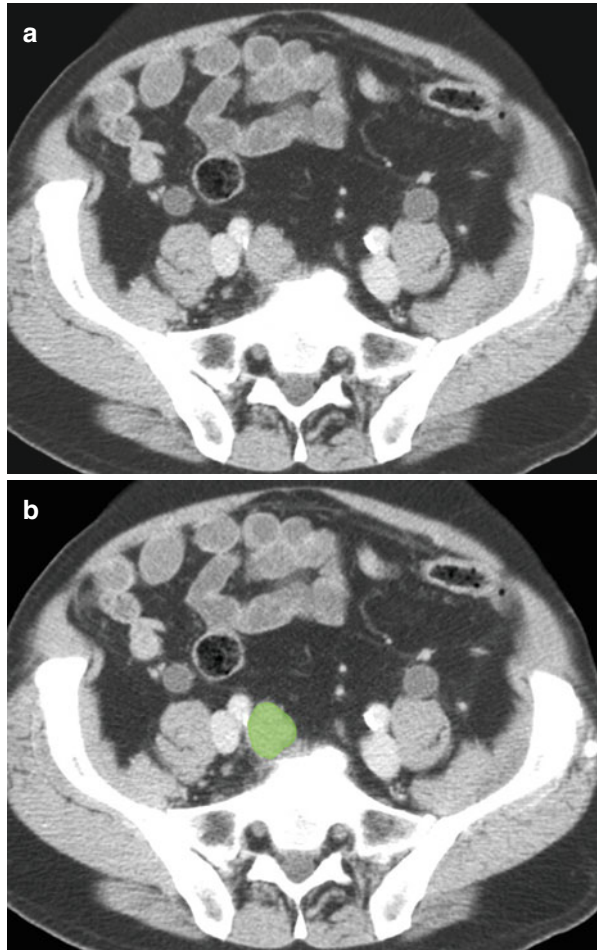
(a, b) Axial CT image showing metastatic presacral lymph node (*green*) in a patient with prostate cancer
